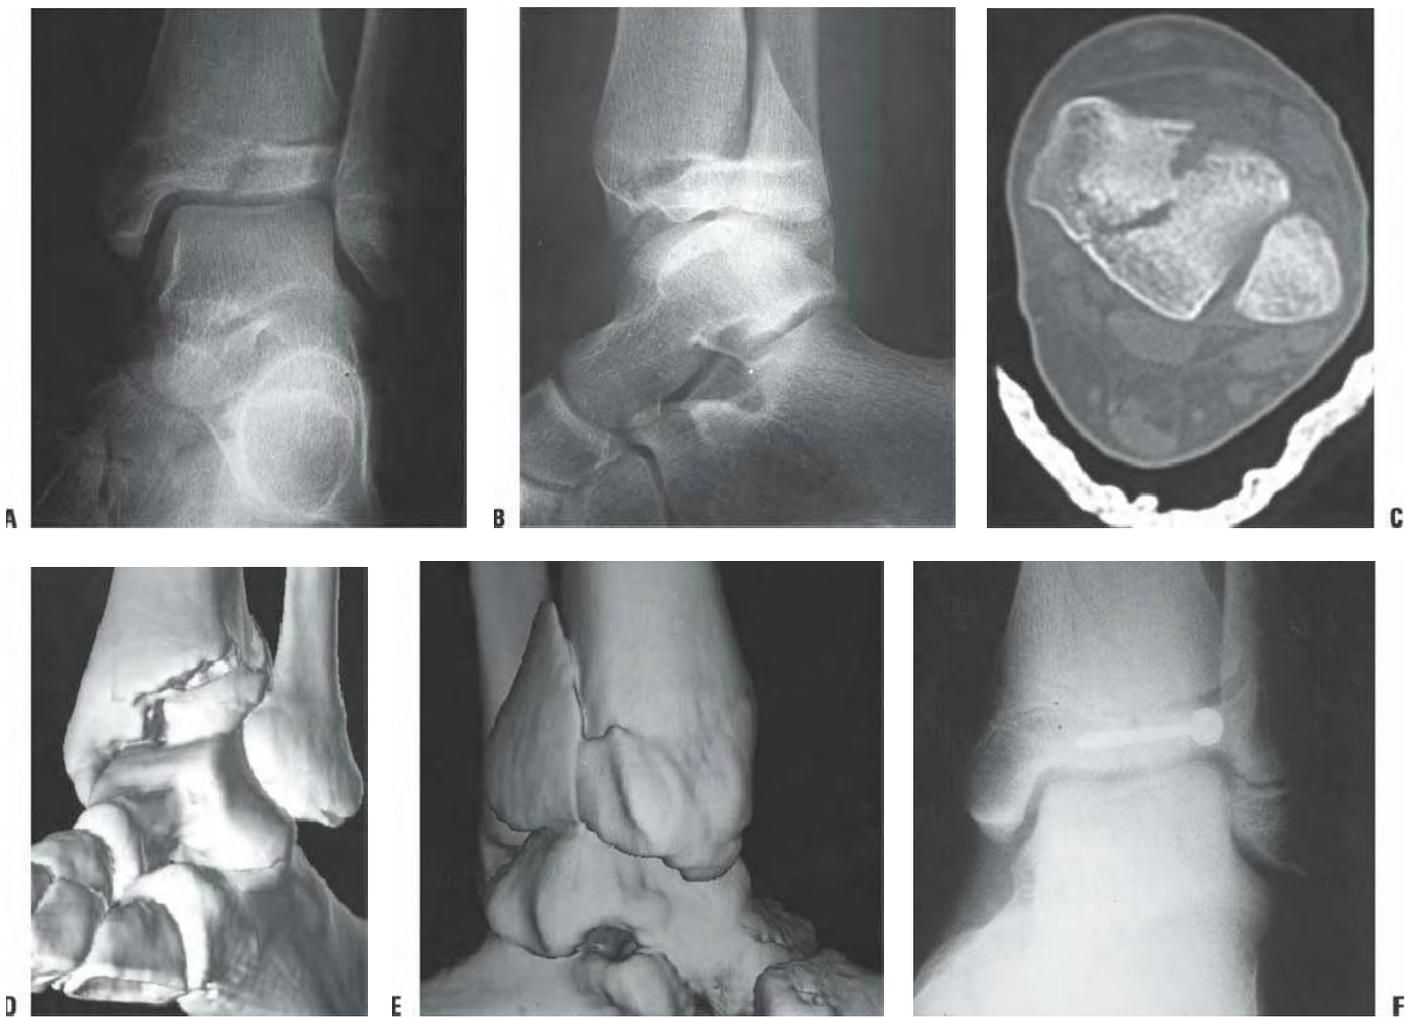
Triplane fracture of the distal tibia in a 12-year-old girl with CT evaluation. A: The anteroposterior radiograph shows a Salter-Harris type III fracture. B: The lateral radiograph shows an apparent Salter-Harris type II fracture. This indicates a triplane injury. C: CT through the epiphysis confirms a two-part fracture. D, E: Three-dimensional reconstruction demonstrates the fracture from the anterolateral and the posteromedial views. F: Closed reduction was unsuccessful. Arthroscopically assisted open reduction was performed. The fracture was stabilized with a single anterolateral cannulated screw inserted percutaneously.
